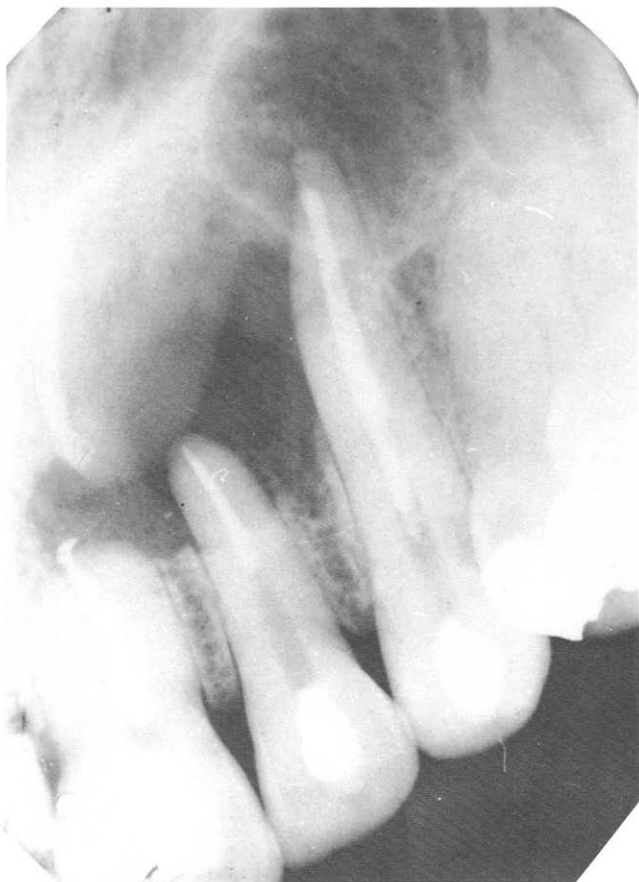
Radiograph of teeth 9 to 11 demonstrating large periradicular lesion 17 months after initial endodontic treatment.
